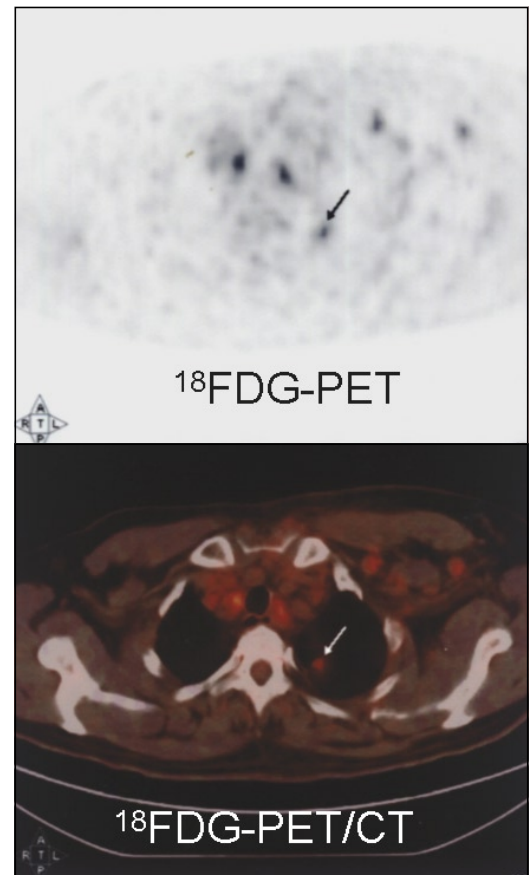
^{18}F -FDG-PET/CT fusion image showed multiple focal areas of increased ^{18}F -FDG uptake in the region of mediastinum, left axilla and lung.
